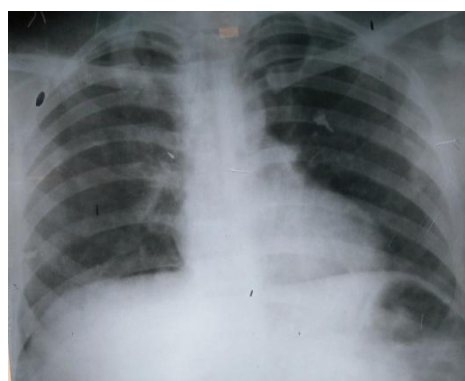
Showing Xray picture of patient with no evidence of free gas under diaphragm
